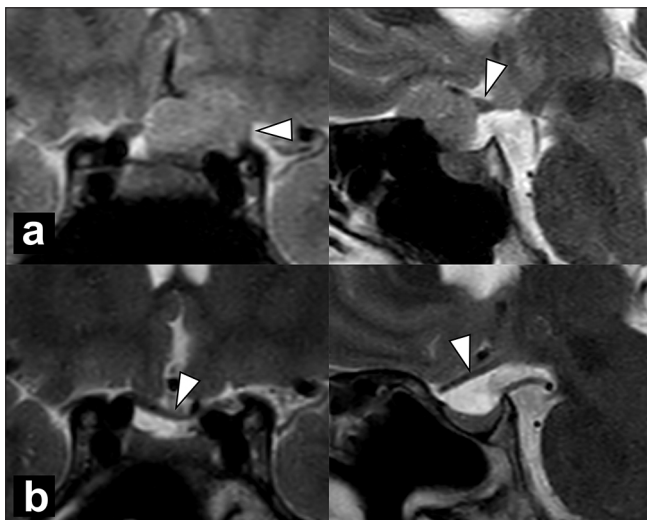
Preoperative and postoperative magnetic resonance imaging of the current case. (a) Preoperative coronal (left) and sagittal (right) T2-weighted images show a tuberculum sellae meningioma. The tumor was bending the optic nerve upward (arrowhead). The patient was pregnant and, therefore, could not receive preoperative examinations using gadolinium-enhanced contrast imaging. (b) Postoperative coronal (left) and sagittal (right) T2-weighted images show no obvious residual tumor. The optic nerve, which the tumor had bent, has recovered to its normal position (arrowhead).
